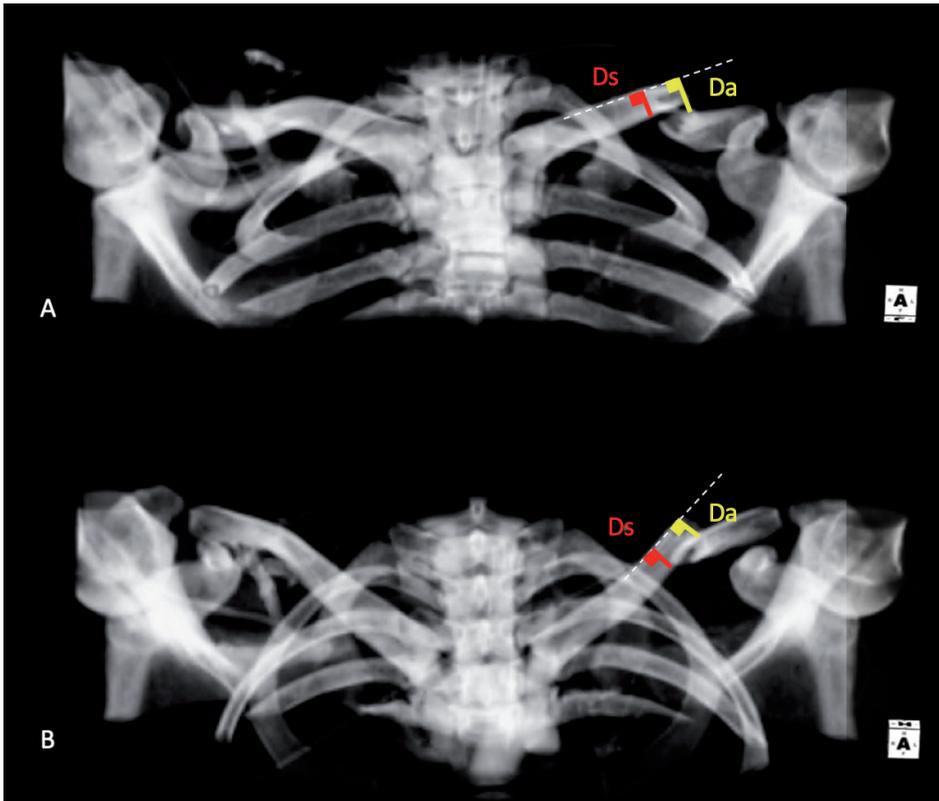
Example of a Digitally Reconstructed Radiograph (DRR) of the same clavicle fracture in A) 15° caudo-cranial and B) 15° cranio-caudal view and the standardized measurements. Ds = diameter of the clavicle. Da = absolute amount of vertical displacement.
